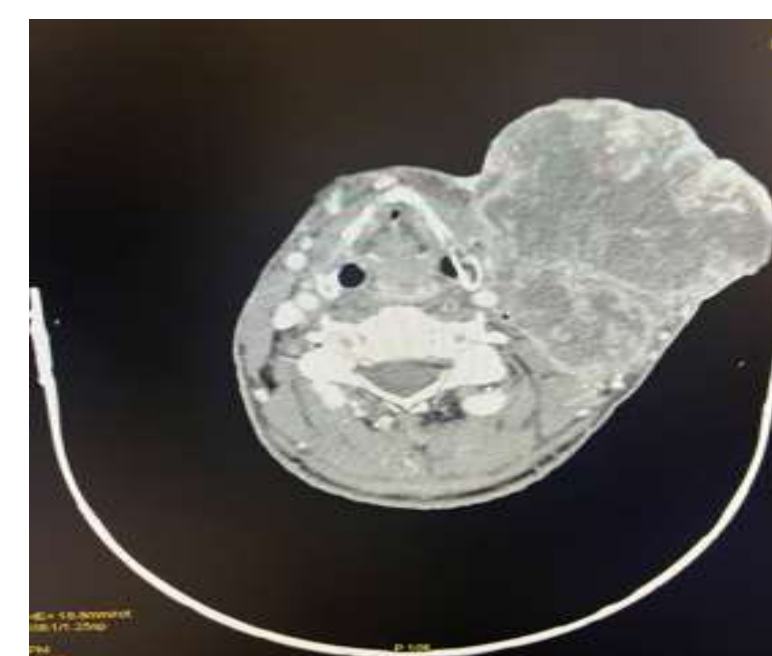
Axial slice of a contrast-enhanced cervical CT scan showing a large lobulated mass with heterogeneous enhancement, containing areas of necrosis ■
